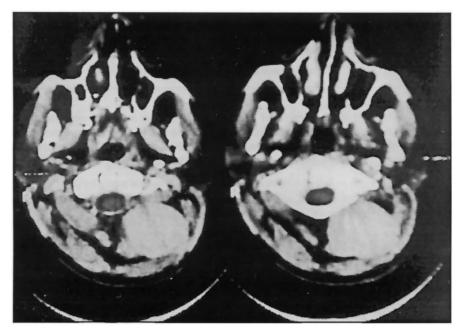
CT scan showing a voluminous hyperdense extracranial lesion in the left suboccipital region with aneurysmatic characteristics.
